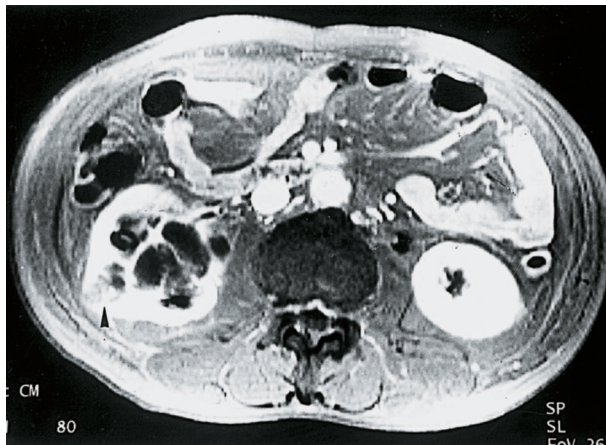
MRI of the right kidney showing 1 cyst with soft tissue in the septum (arrowhead).
